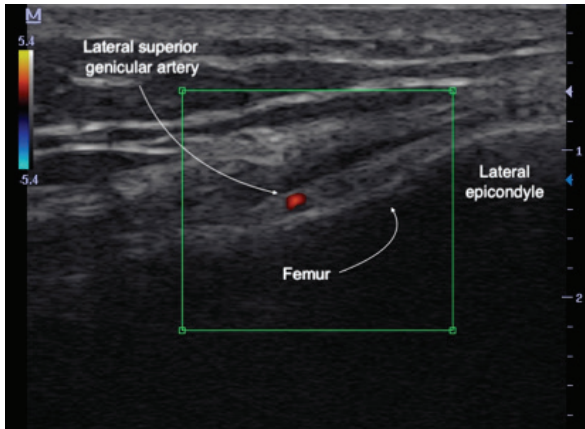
Color Doppler image demonstrating the superior lateral genicular artery (sagittal plane).
